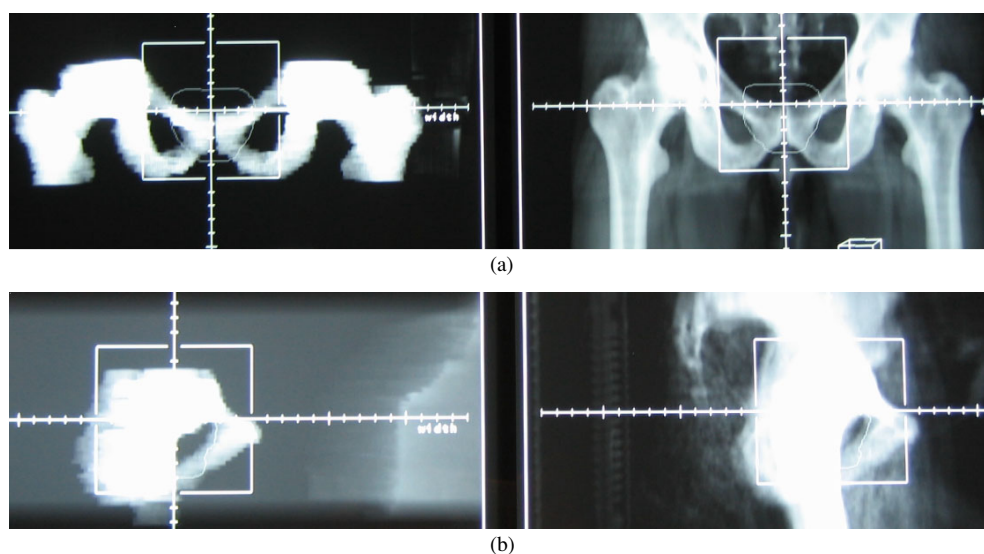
Comparison of MRI-based DRRs (left) and CT-based DRRs (right) for a prostate patient: (a) coronal view and (b) sagittal view.
